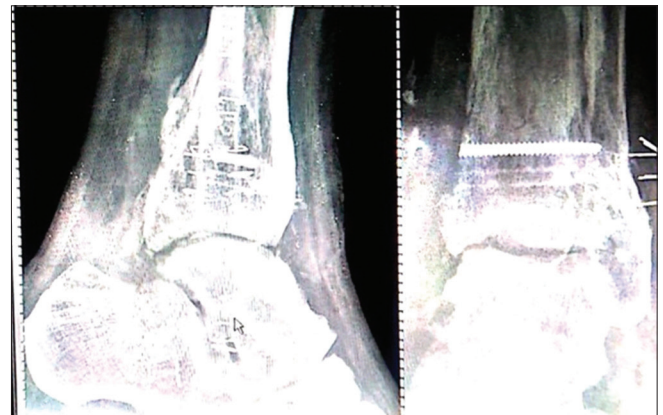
Post-operative X-ray: Lateral and AP view reveals successful excision of the heterotopic bone
